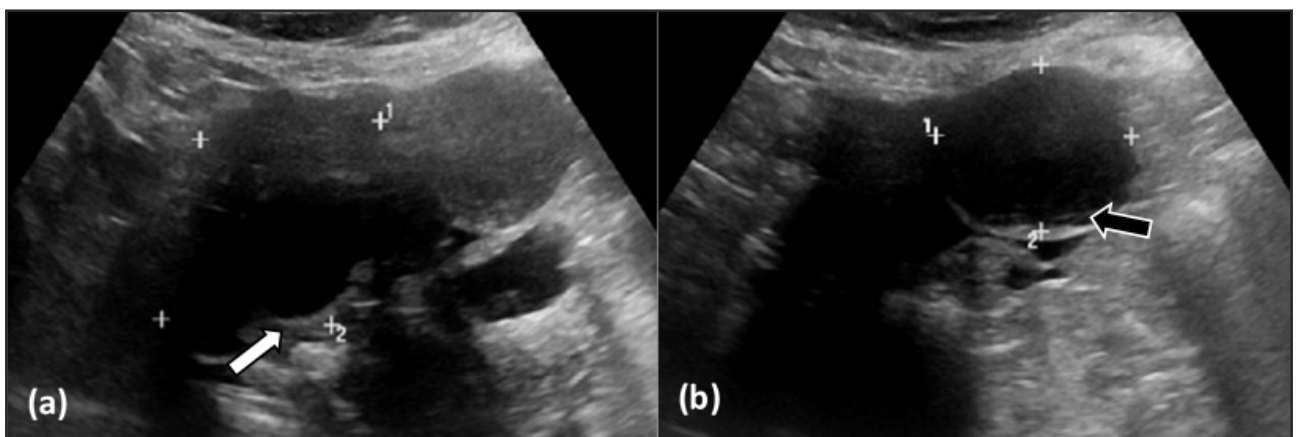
Ultrasonography of Pelvis showing (a) Right ovary showing multi-loculated cystic lesion with thick wall (White arrow) measuring 6 x 5 cm, (b) Left ovary showing well-defined cystic lesion with thickened wall and turbid content (Black arrow) measuring: 4.5 x 3.5 cm.
